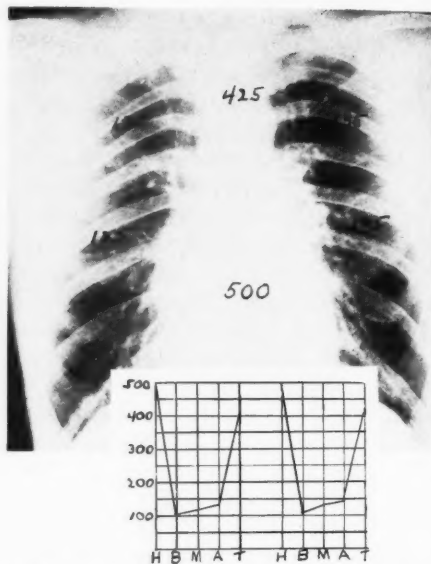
Roentgenogram of a normal lung showing the lung densities as observed by the photometer. When readings are recorded on a chart, the chart gives a capital U for each lung, or a double U for both lungs.
